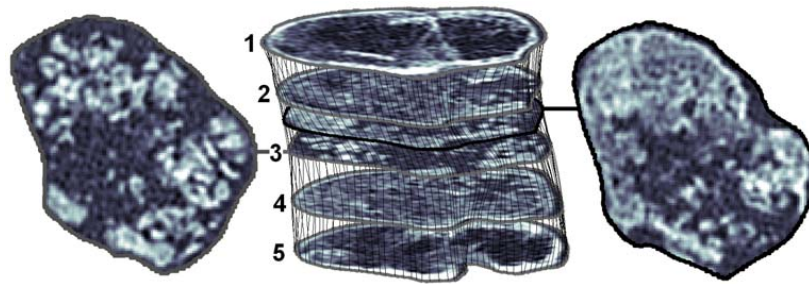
The ROIs on the top (1), middle (3), bottom (5) and quartiles (2 and 4) of the modelled section are drawn manually. These ROIs are divided into an equal number of points which are used to automatically generate ROIs for all CT images inbetween. A manually drawn ROI is seen on the left and an automatically generated ROI on the right.
